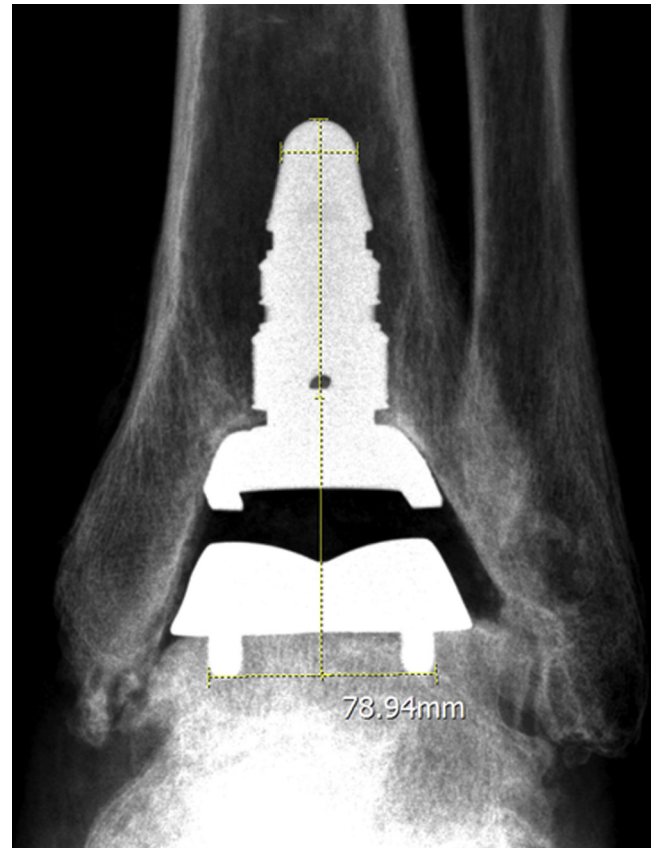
Implant migration measurements for the nonstemmed component. Using anteroposterior radiographs, measurements were taken from the apex of the tibial component to the mid-saddle of the nonstemmed talar component.
